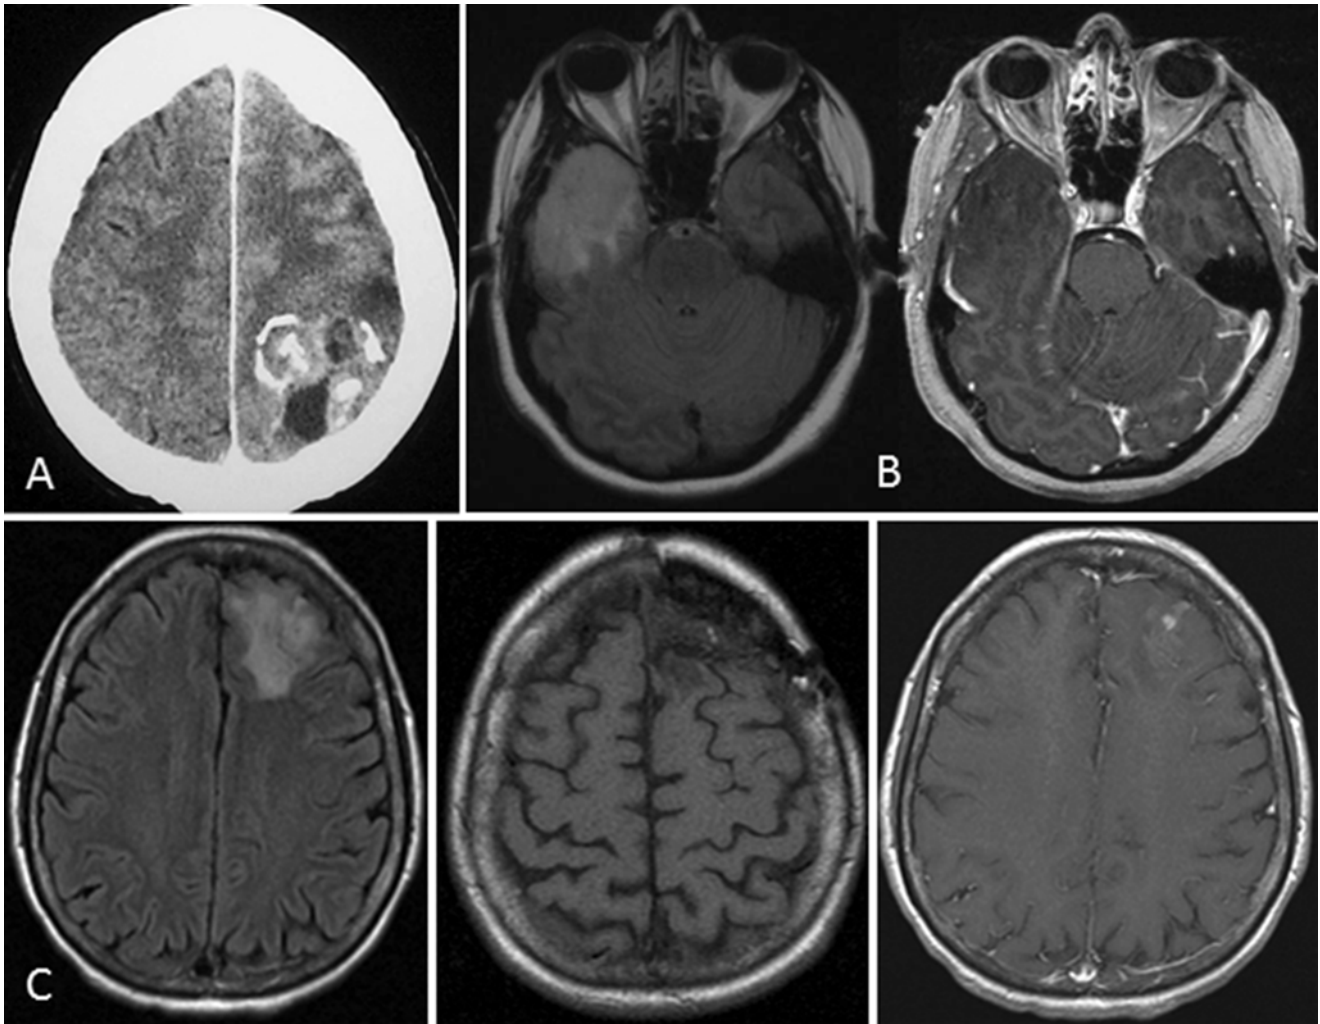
Classic imaging features of ODG. (a) computed tomography scan showing hyperdensities consistent with calcification and possibly, microhemorrhages; magnetic resonance imaging (MRI) of AO with (b) FLAIR, (c) T1w, and (d) T1wGd sequences
